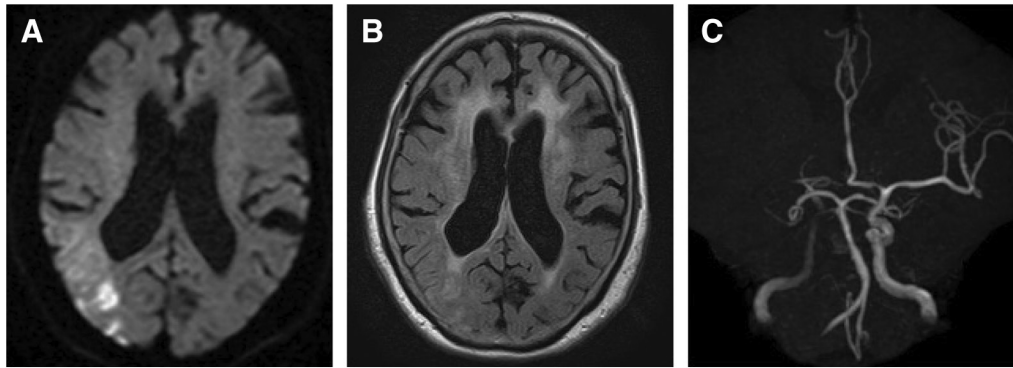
Initial MRI images on admission. (A and B) DWI showing a hyperintense area in the right MCA territory with few signal alterations on FLAIR. (C) MRA indicates the occlusion of M1. DWI: diffusion-weighted imaging; MCA: middle cerebral artery
